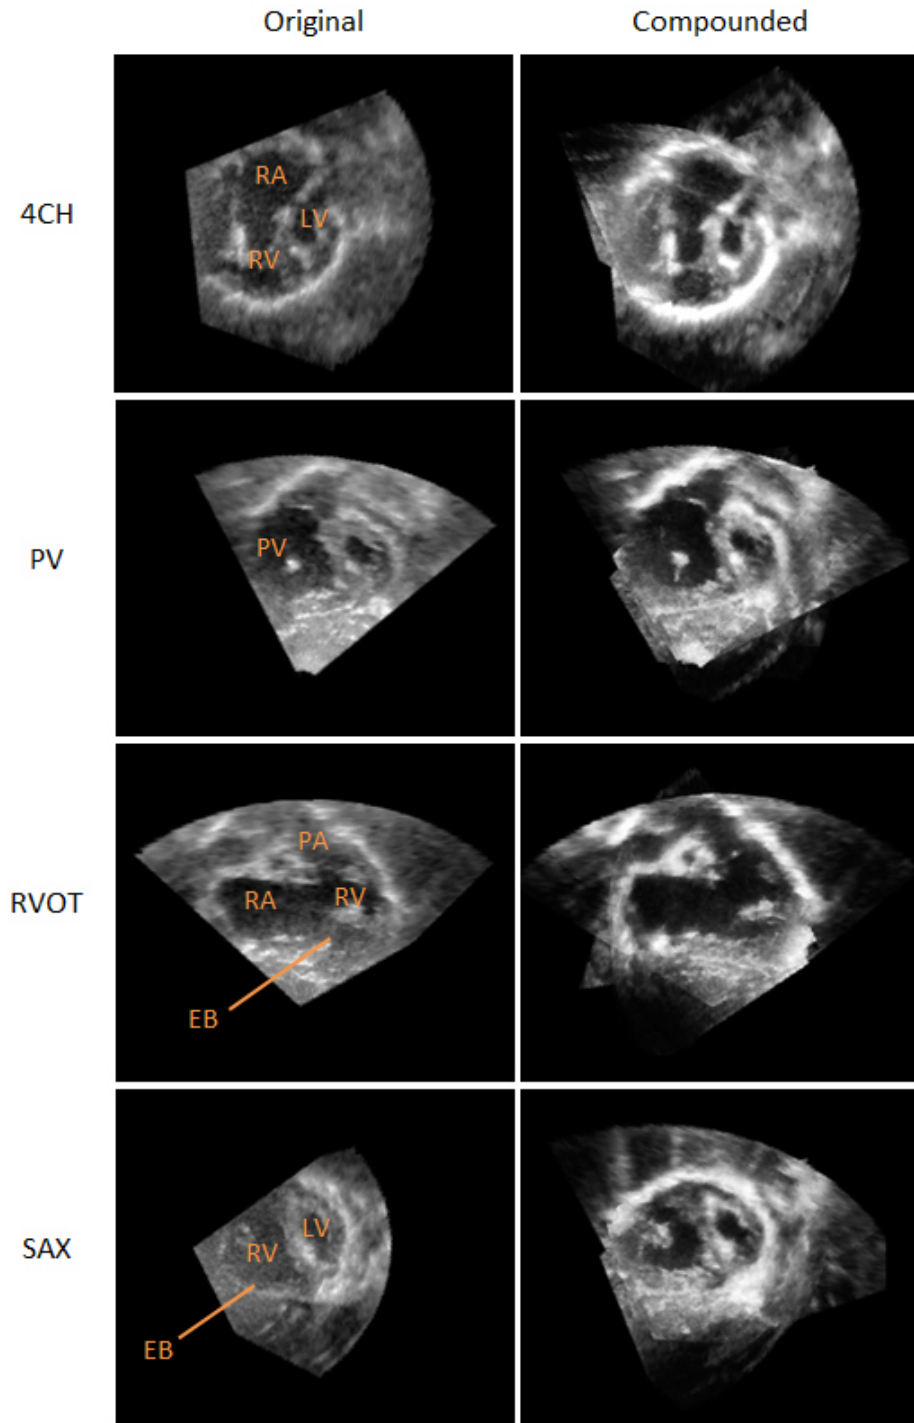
Slices from 3D echo images on HLHS4 patient data. Original and compounded images are presented in the following view angles: 4CH (apical four chamber), PV (pulmonary valve), RVOT (right ventricle outflow track) and SAX (short axis). My compounded images shows less noise, more contrast and with RV and PV well presented in single volume. (LV = left ventricle; RV = right ventricle; RA = right atrium; PA = pulmonary artery; EB = endocardial border)
